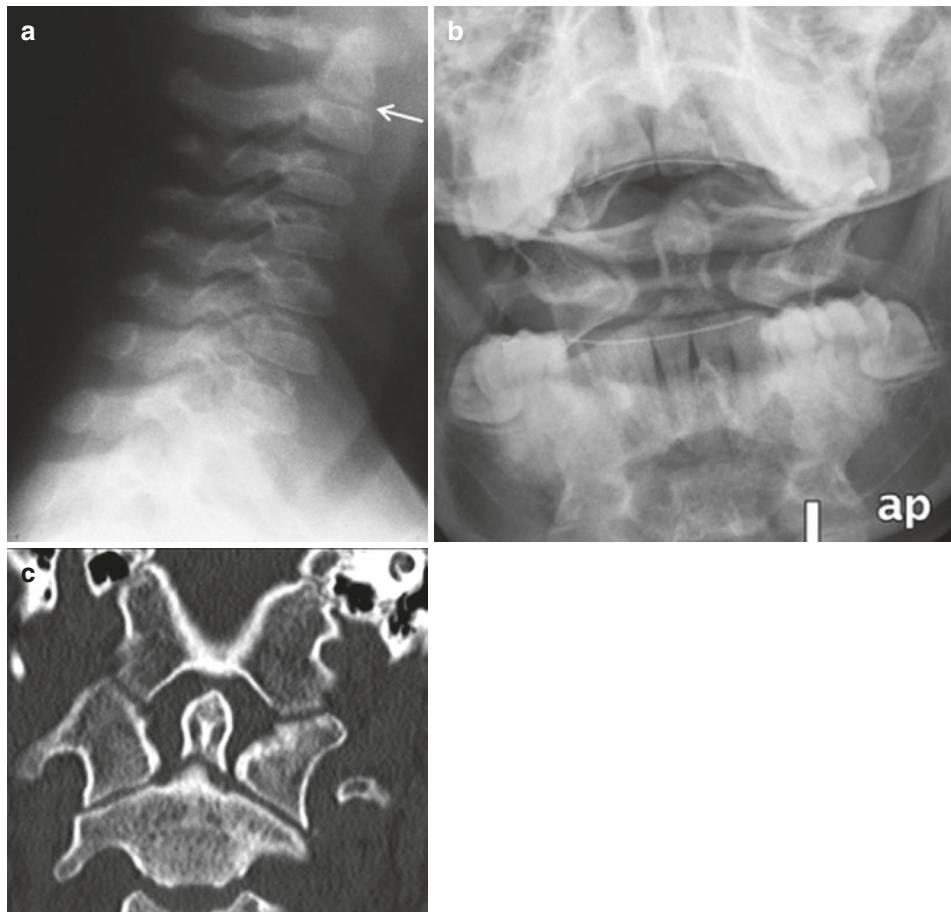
(a) Lateral radiograph of the cervical spine in a 3-year-old boy shows a normal subdental synchondrosis with subchondral sclerotic lines (arrow). (b) Open-mouth
